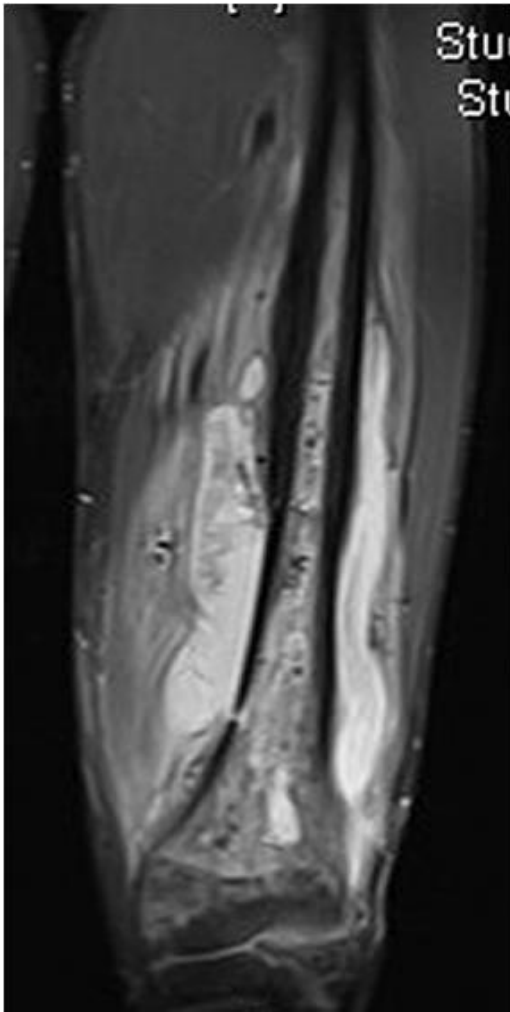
MRI study of a patient with chronic osteomyelitis of the femur; signs of infection are medullary necrosis, abscess formation and sequestrum (41)
